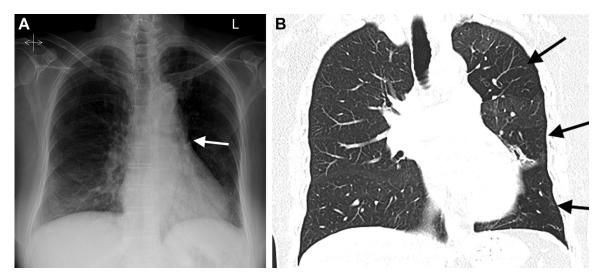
A, Posterior-anterior chest radiograph in a 73-y-old man with a history of Swyer-James-Macleod syndrome showing a smaller volume, hyperlucent left lung with smaller left hilar vascular shadow (arrow). B, Coronal CT image on lung windows in the same patient showing a smaller volume left lung with air trapping (arrows).
